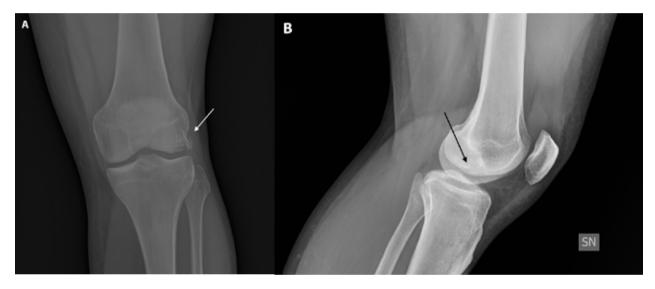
Preoperative plain radiographs: (A) standing anterior-posterior view; (B) lateral view.
